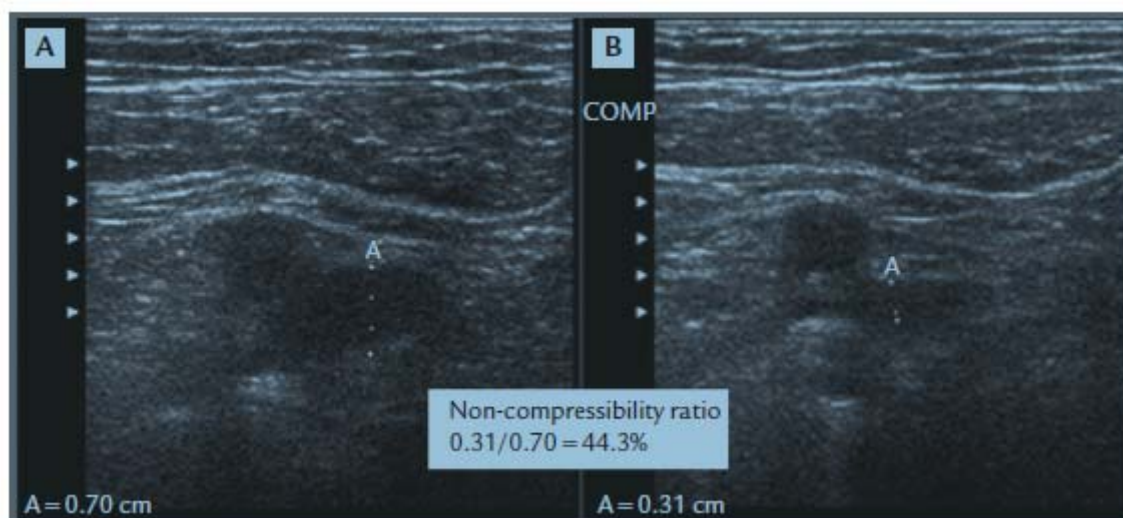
Non-compressibility ratio of venous thrombosis using sonographic transverse sectioning. A. Diameter of vein before compression. B. Diameter of vein after compression.⁽²⁾
